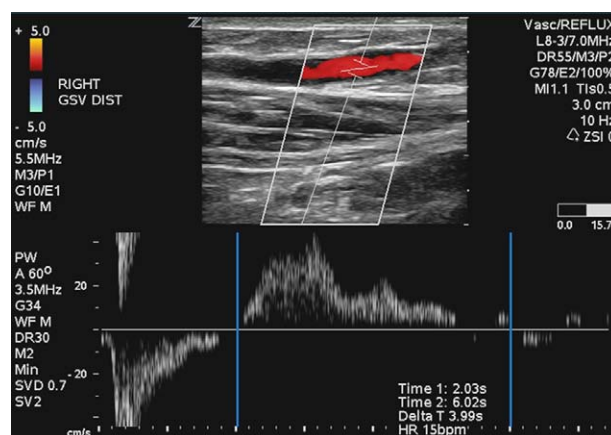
Venous duplex ultrasound demonstrating reflux in the great saphenous vein. Blood flow direction is determined after increasing central venous return with rapid cuff inflation then deflation. Flow in the direction of the feet is because of incompetent valves, as shown in red in the color image and above the baseline in the pulse Doppler. The Doppler spectrum quantifies the duration of reflux, and in the example above it is ≈4 seconds.
